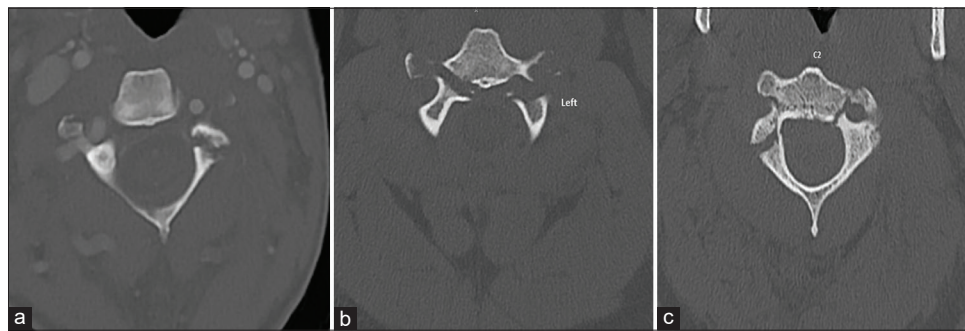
CT C-spine [axial] shows (a) left pars fracture, (b) bilateral pedicle fracture, (c) bilateral pedicle fracture.
